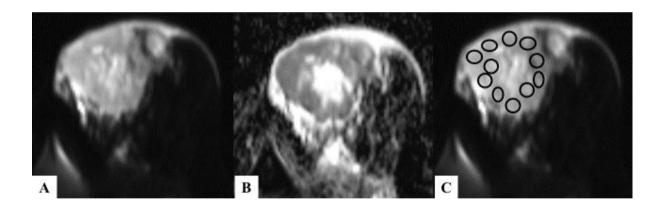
DWI & ADC sequences of a patient with infiltrative ductal carcinoma:(A) DWI and (B) corresponding ADC images showing peripheral area of restriction of diffusion within the lesion present in left breast- suggestive of malignant etiology (C) DWI image demonstrating the method of placing multiple ovoid ROIs (each measuring ~ 25 mm²) in the areas of restricted diffusion for calculation of mean ADC value.
